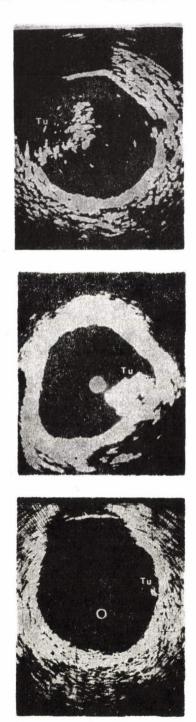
i Intravesical ultrasonogram of bladder tumours of various sizes
